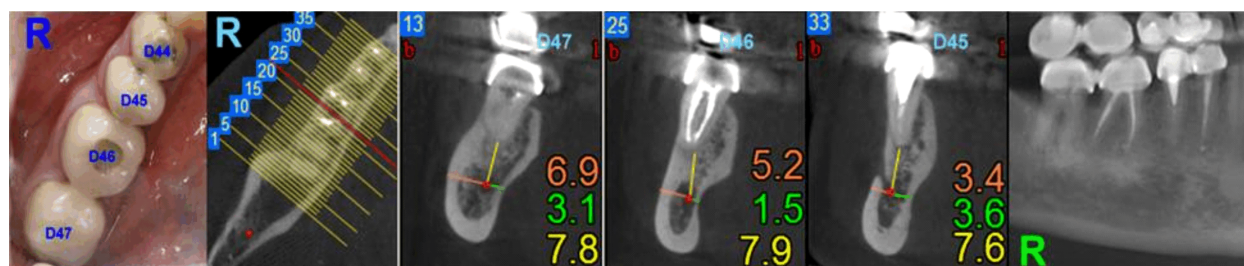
CBCT: right hemi-mandible. Bucco-lingual sections at the level of teeth 4.5, 4.6, 4.7. Orange – MC-BS distance; yellow – MC-T distance; green – MC-LS distance. CBCT: Cone-beam computed tomography; MC-BS distance: Distance between the mandibular canal and the buccal (lateral) surface of the mandible; MC-T distance: Distance between the mandibular canal and the root apices of the second premolar, the first and second molars; MC-LS distance: Distance between the mandibular canal and the lingual (medial) surface of the mandible.
